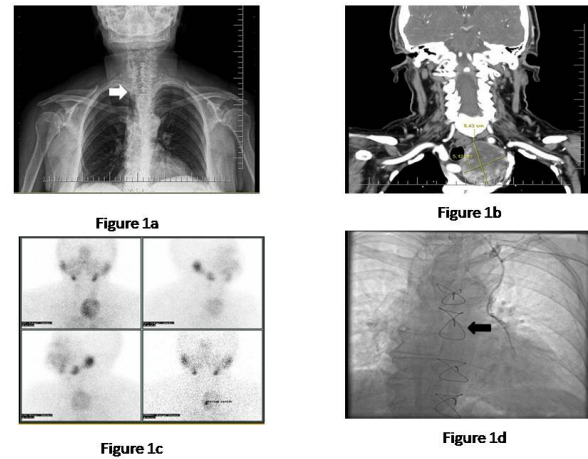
1a; preoperative chest X-ray, white arrow showing the tracheal deviation. 1b; preoperative computed tomography of the patient showing the retrosternal goiter that deviated trachea to the right. 1c; thyroid scintigraphy. 1d; coronary angiography, black arrow showing the patent LITA-LAD anastomosis.
